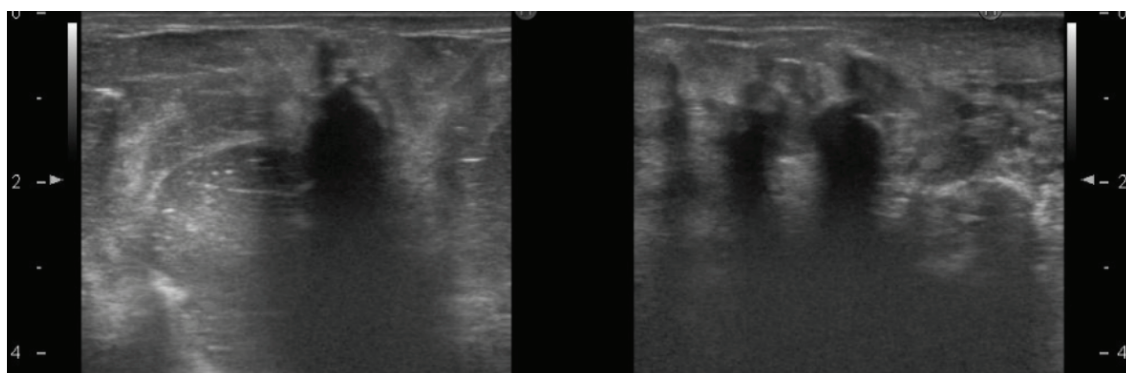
Ultrasound images of both breasts show ill-defined isoechoic masses with posterior acoustic shadow
